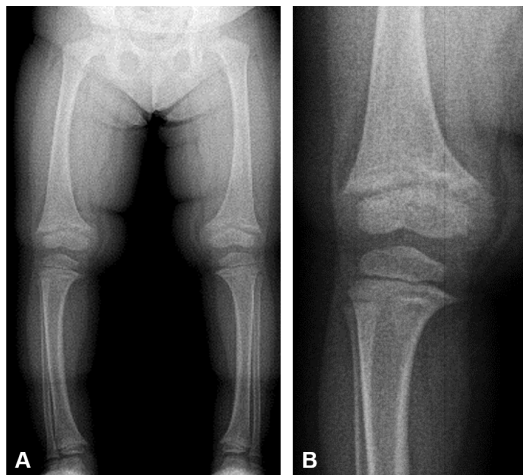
Radiographic findings of a 39-month-old patient with X-linked hypophosphatemic rickets (XLH). (B) is the image of the right knee of (A). Radiologic findings of genu varum, metaphyseal flaring and decreased bone density are evident.
